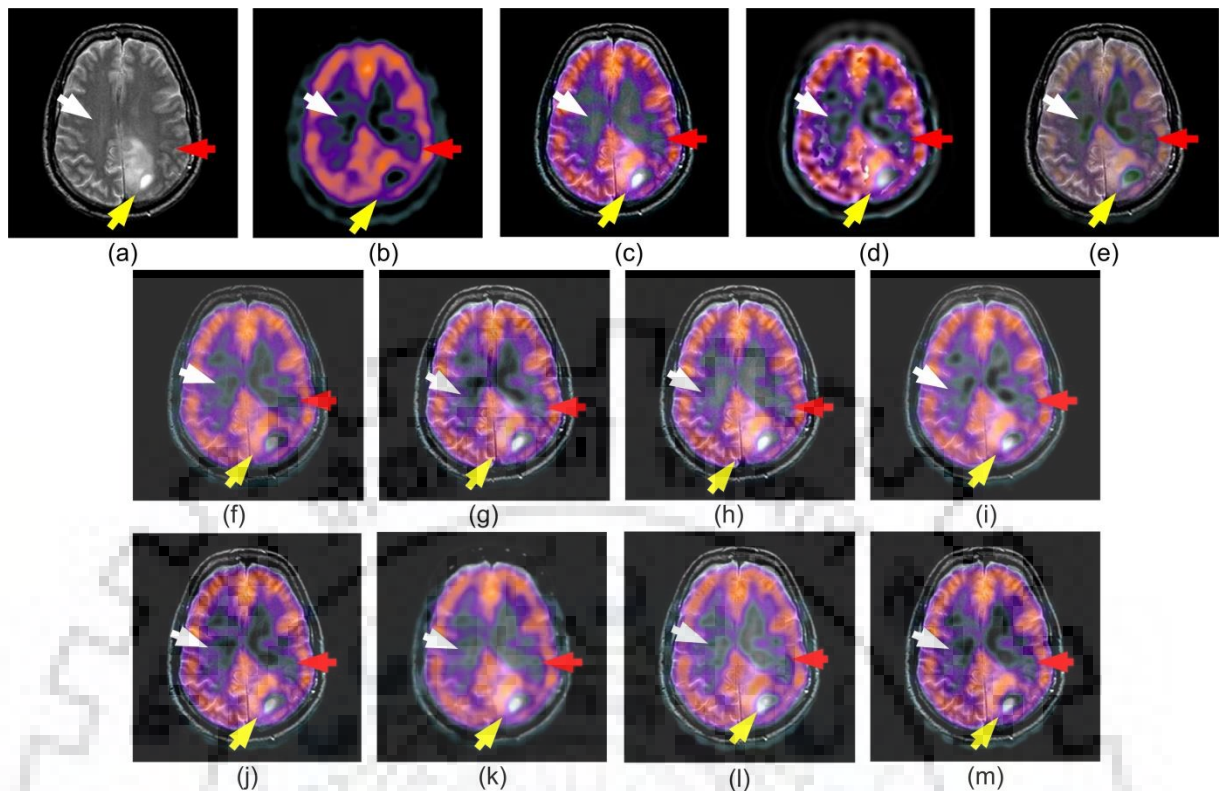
Input image (a) MR image (b) SPECT image, qualitative comparisons of fused images obtained by (c) Allanki and Bindu, 2016 [157] (d) Bhatnagar et al., 2013 [18] (e) Li et al. (GFF), 2013 [94] (f) Yang and Li (OMP), 2012 [192] (g) Liu et al., (MST-SR) 2015 [109] (h) Ganasala and Kumar, 2016 [48] (i) Yang et al., 2017 [203] (j) Yang et al., 2015 [200] (k) Zhu et al. (HMDS-GDGF), 2018 [218] (l) Yang et al. (NSCT-Type2 Fuzzy), 2016 [201] (m) Proposed SDL-MIF method
